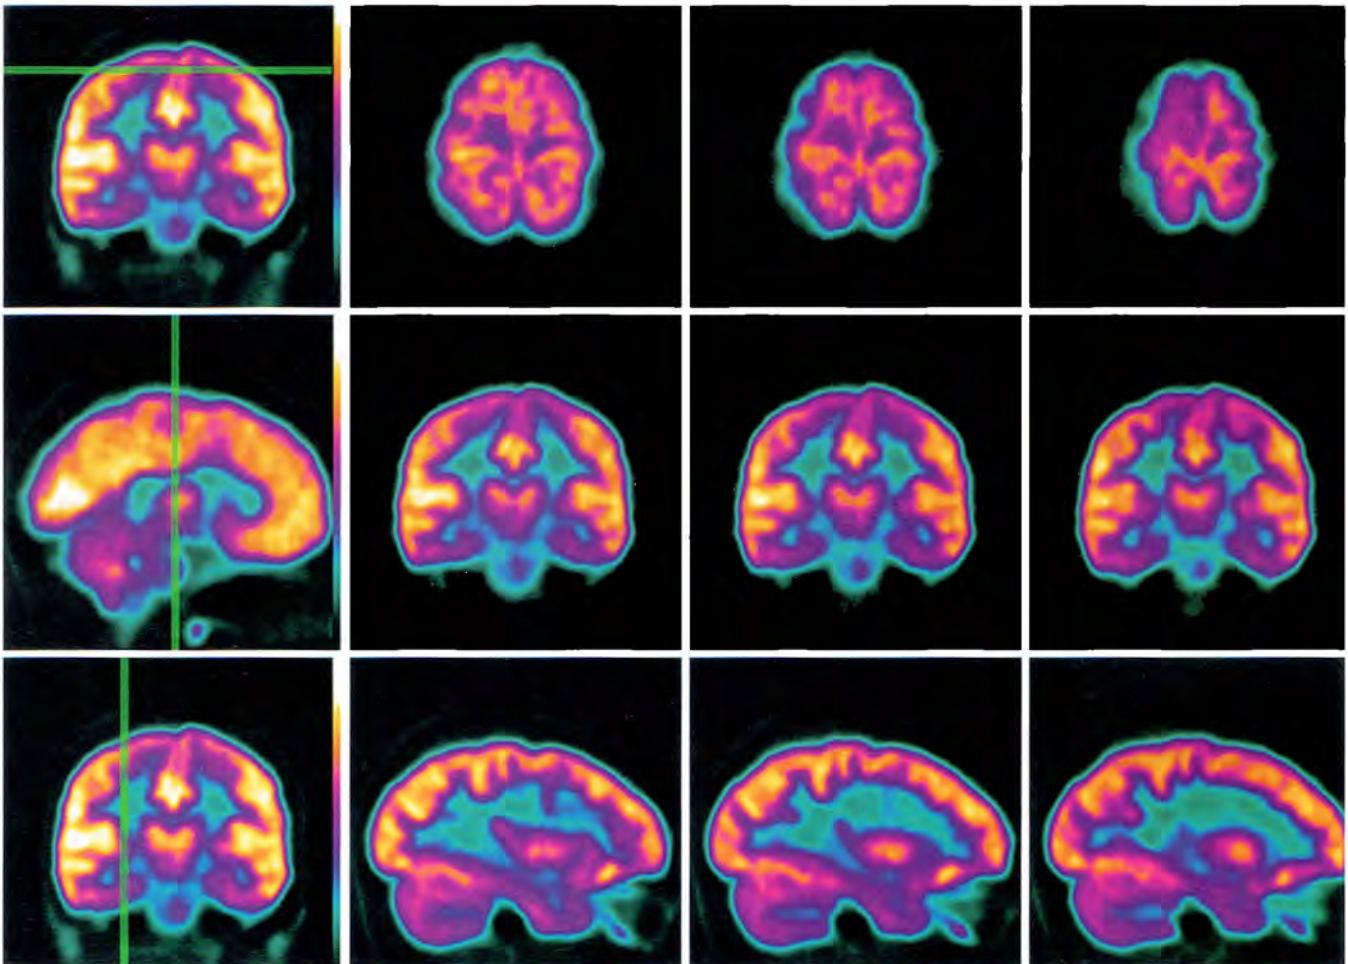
This interictal FDG-positron emission tomography study demonstrates decreased metabolism at the frontal parameal region. This may represent a seizure focus site and is best visualized in the middle row on the coronal view.
